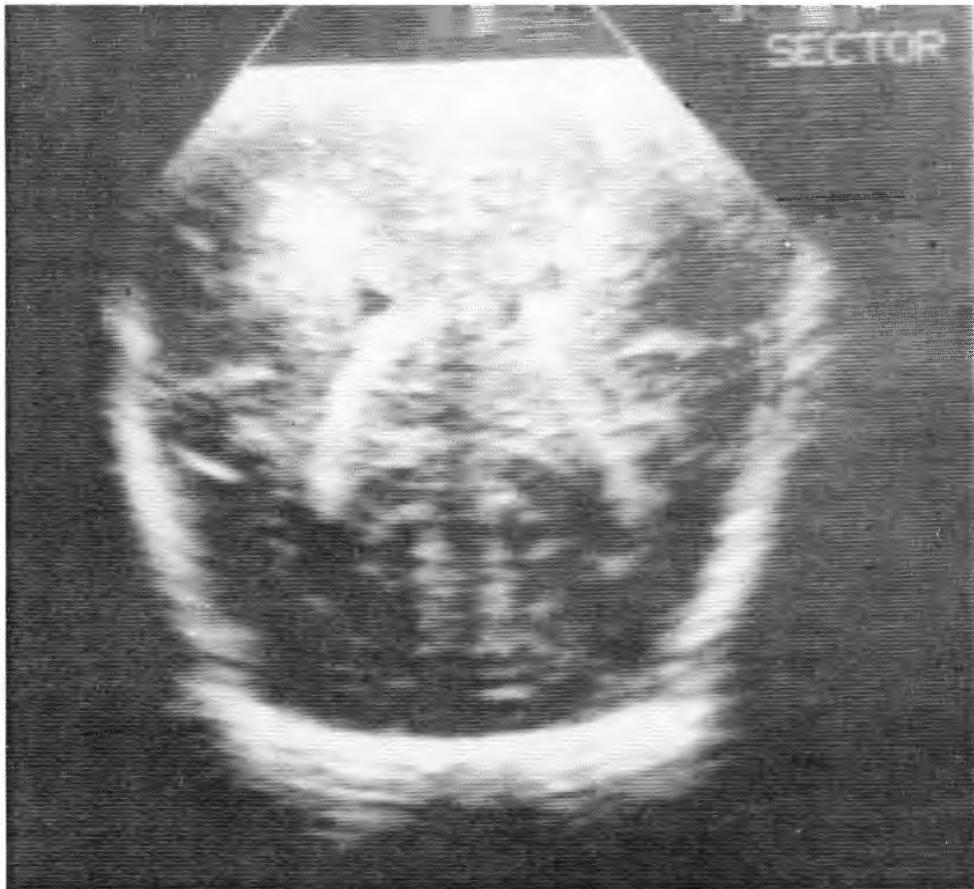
Example of an image obtained by means of ultrasonography (coronal view).
